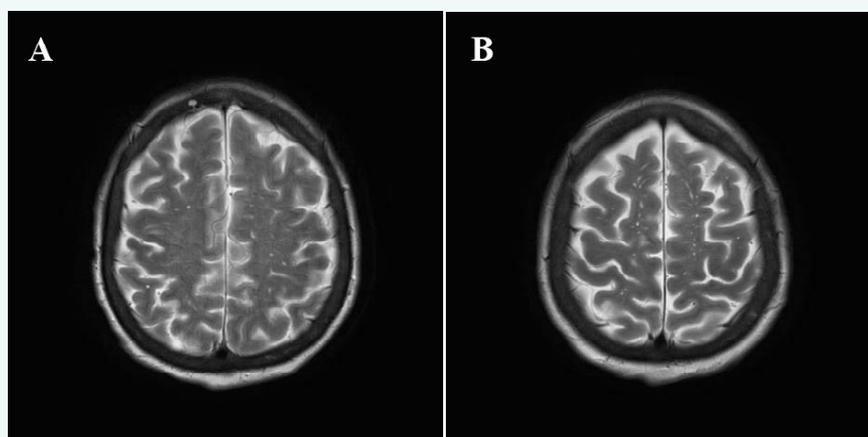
MRI Brain T2 – Multiple small supratentorial diffusion restrictions.
